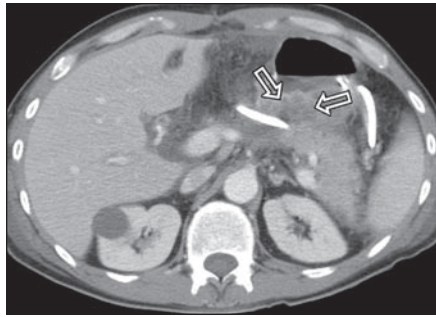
52-year-old man 7 days after pancreaticoduodenectomy for pseudotumoral cholangitis. Transverse contrast-enhanced helical CT scan of abdomen shows small fluid collection (arrows) without air bubbles very close to anastomosis. Both radiologists correctly identified small perianastomotic fluid collection and suspected presence of pancreatic fistula, but clinical and biologic findings were negative for pancreatic fistula on postoperative day 7 and at follow-up until hospital discharge. Collection was not present on CT scan obtained on postoperative day 14.
